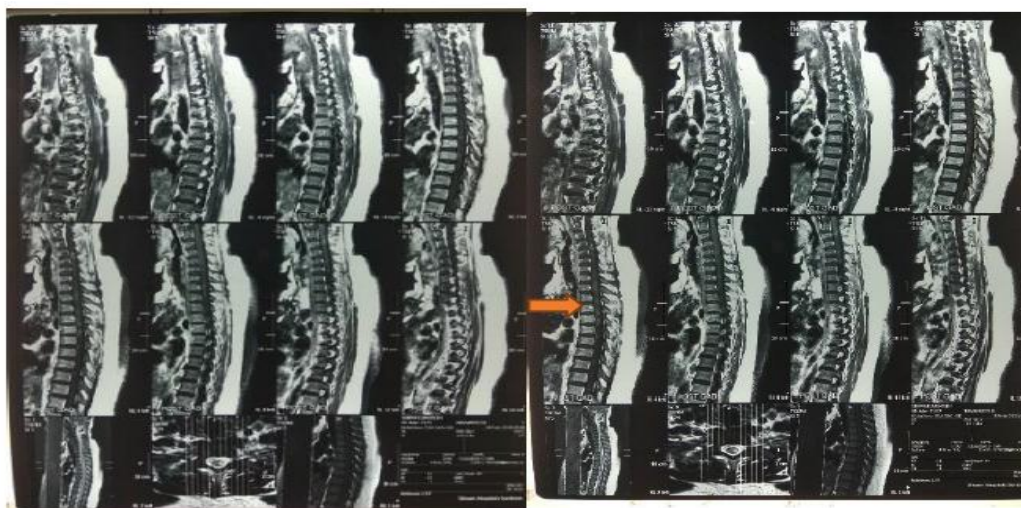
MRI T1 weighted with and without contrast before administration of intravenous immunoglobulin showing multiple patchy enhancing lesions of intra spinal cord & periventricular white matter according to multiple sclerosis.
